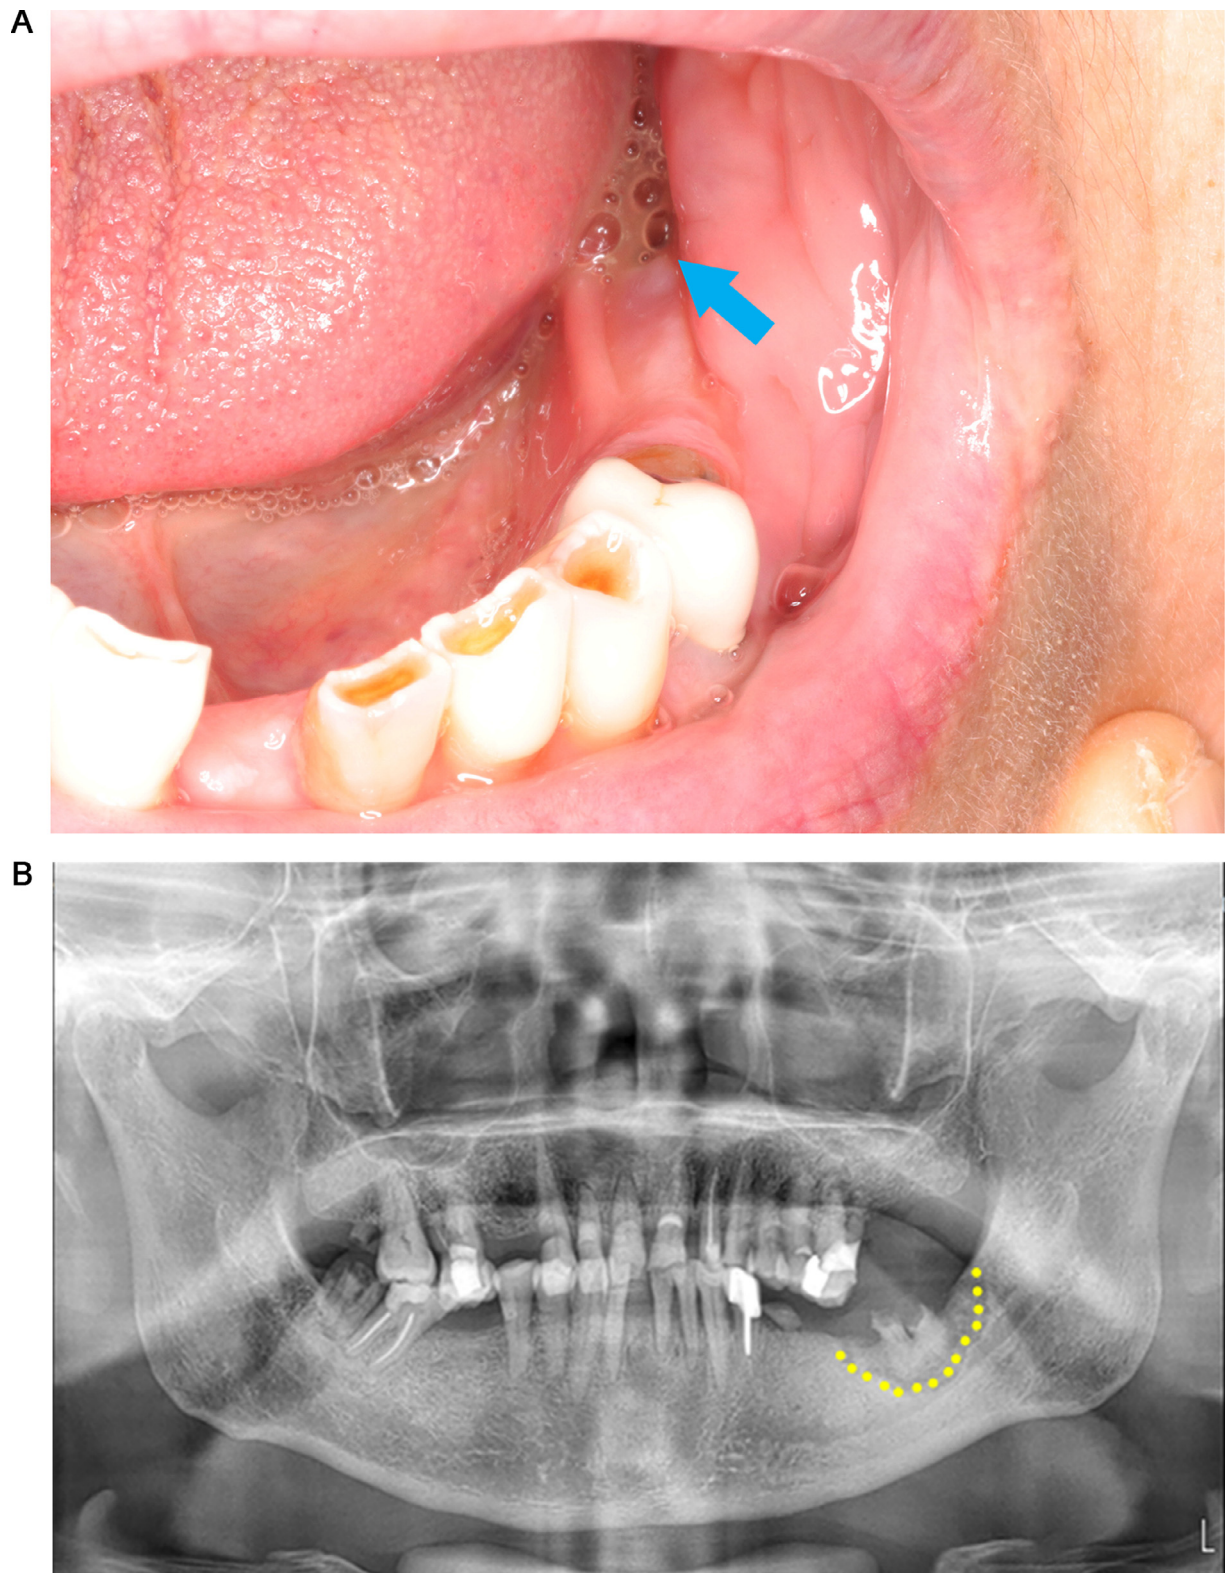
Sequestrectomy and saucerization for stage 2 lesion. *A*, Purulent secretion in the left posterior mandibular region. *B*, Panoramic radiographs before surgery showed osteonecrosis restricted to alveolar bone. *C*, Panoramic radiographs immediately after surgery showed surgical removal of necrotic bone.
